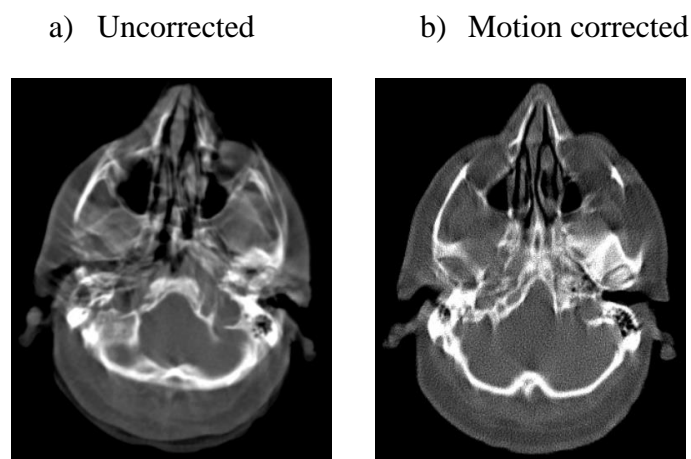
A male patient sneeze during a CT scan a) uncorrected axial slices and b) motion-corrected slices reveal the improvement in image quality.
